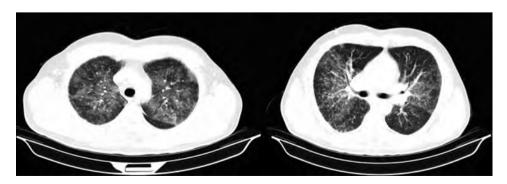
Case 1. Chest CT showing diffuse ground glass opacities in pulmonary parenchyma
